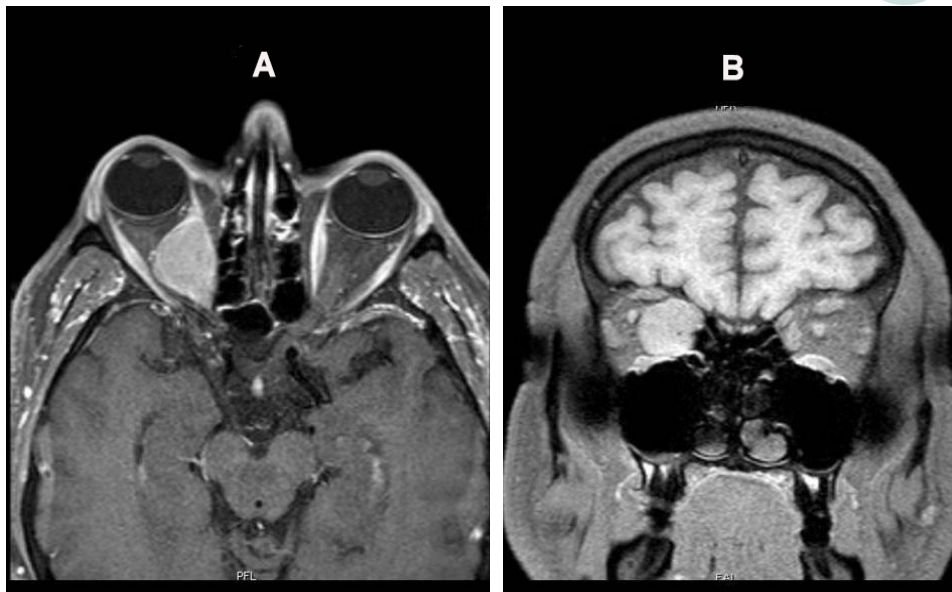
Intraorbital localization of well-differentiated neuroendocrine tumour (G1) of the ileo-cecal valve. MRI of the brain, head and face MRI: sagittal (A) and coronal (B) views. Lesion occupying the great part of the right orbit, and dislocating the optic nerve, though maintaining a cleavage plan from its meningeal structures. MRI: magnetic resonance imaging
